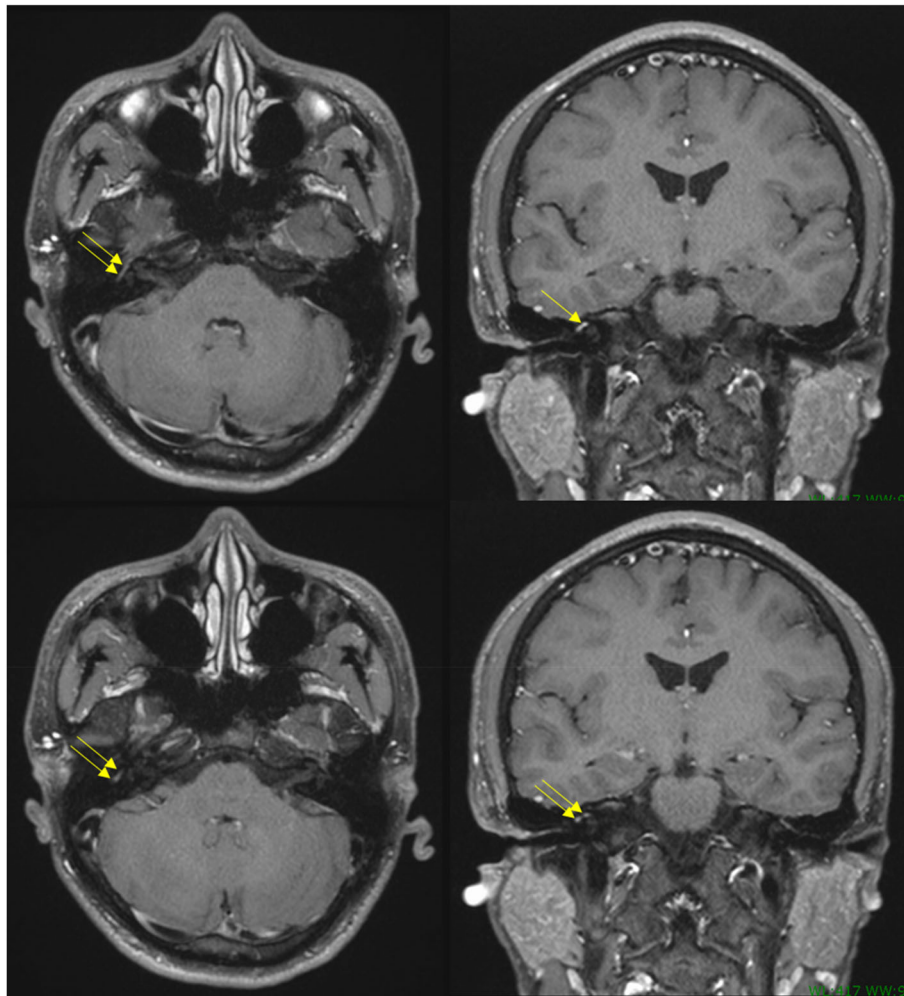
Brain contrast-enhanced magnetic resonance imaging showing asymmetric contrast enhancement of the right facial nerve (yellow arrows).
